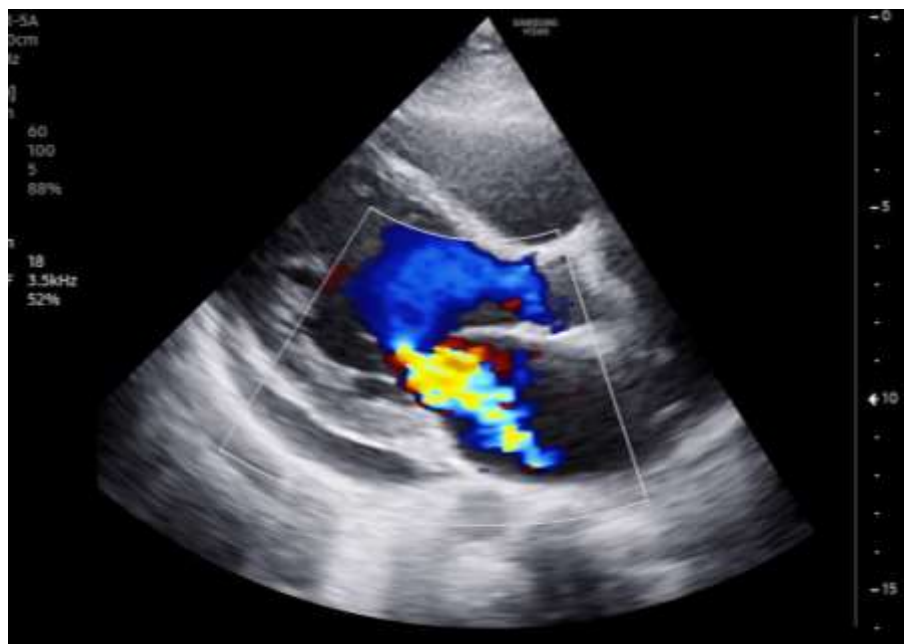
Parasternal long axis view showing a dilated left ventricle with mitral regurgitation and pericardial effusion
